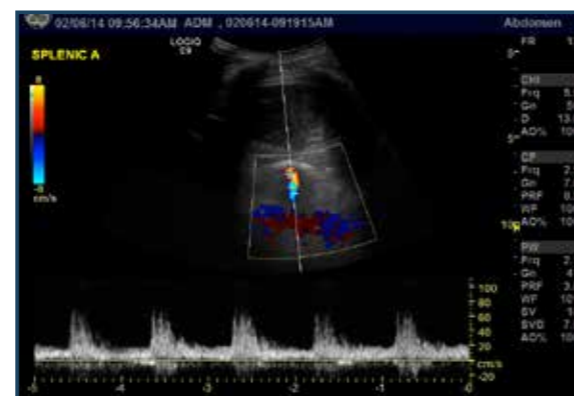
Spectral Doppler trace within the splenic artery aneurysm
